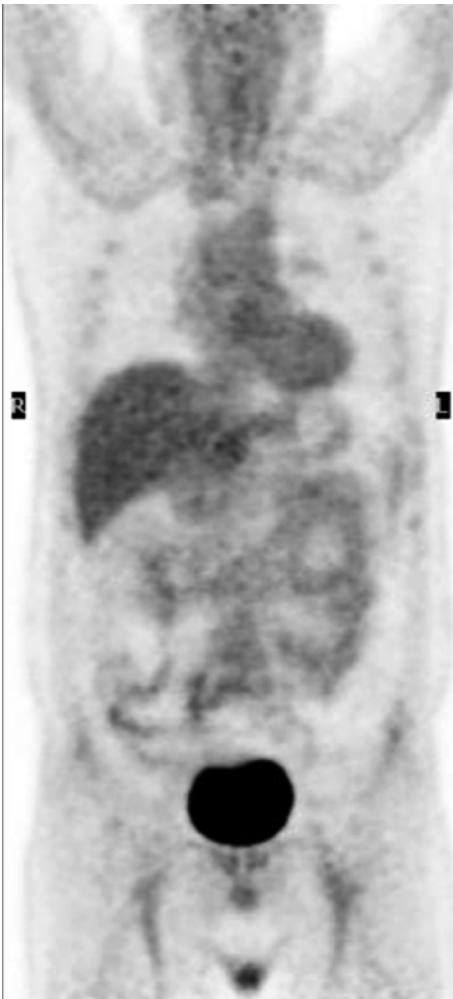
PET/CT after second-line therapy is normal
